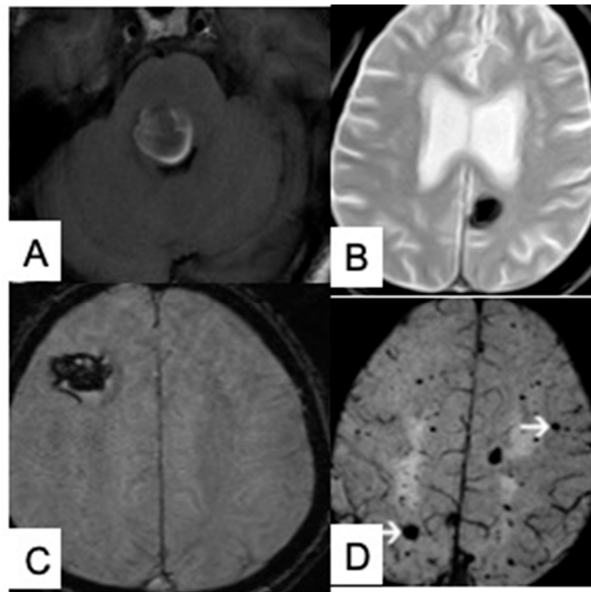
(A) MRI T1W image showing a high-signal hemosiderin ring. (B) MRI T2W image showing a hypointense lesion. (C) SW MRI showing an rt frontal cavernoma. (D) MRI showing multiple cavernomas. Source: Figure by authors.
